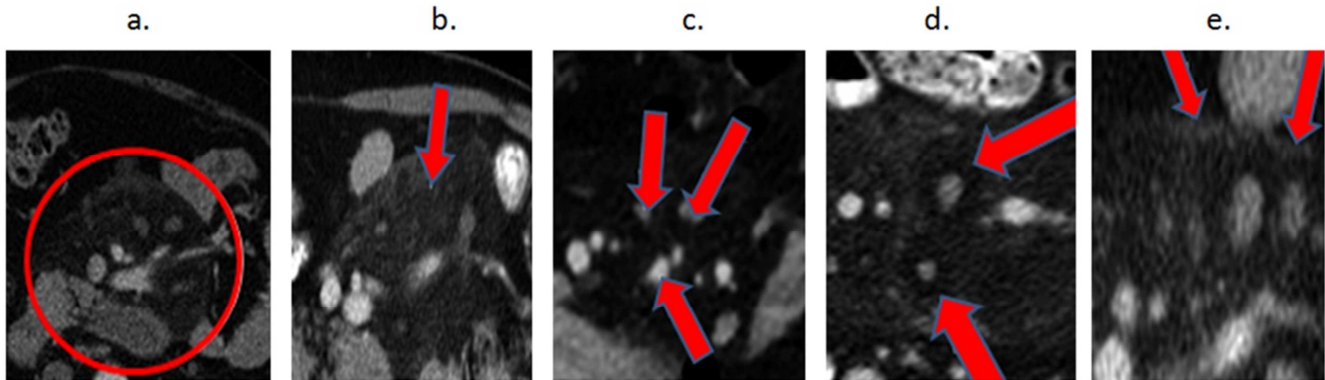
Images and radiological characteristics of mesenteric panniculitis on computed tomography, as described in the literature [9].
